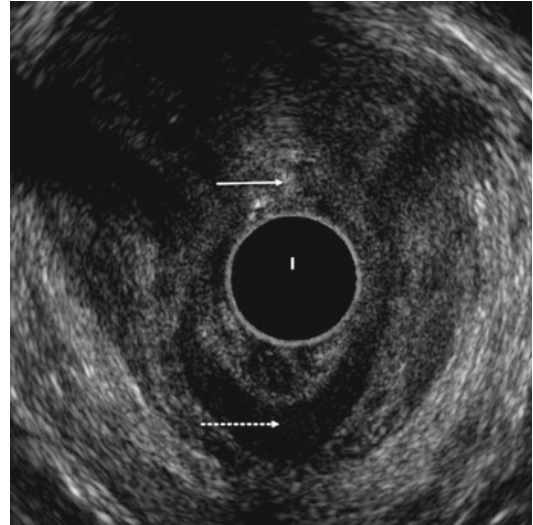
Endoanal ultrasound with an anterior tear of the internal and external anal sphincters (*thin arrow*). Note the retraction of the internal anal sphincter posteriorly (*dotted arrow*)
